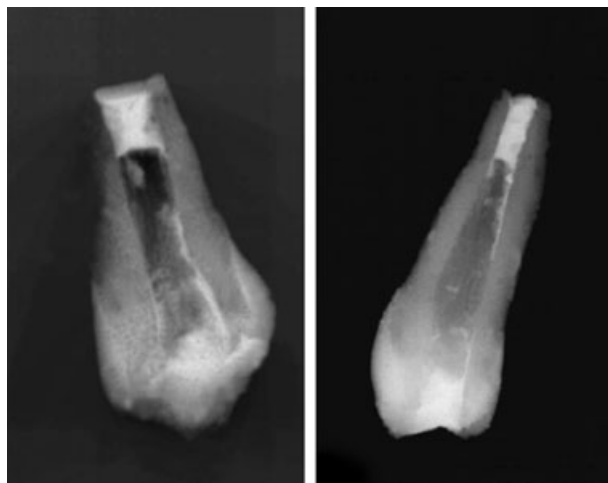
Digital radiograph of two premolars used during the training of the researchers in using mineral trioxide aggregate (MTA) showing correct placement of MTA.
